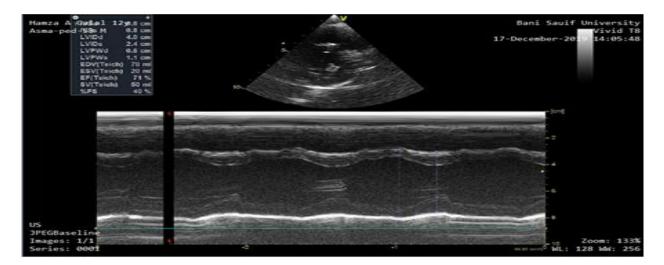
Transthoracic echocardiography (TTE) demonstrating LV systolic function using M-Mode.
